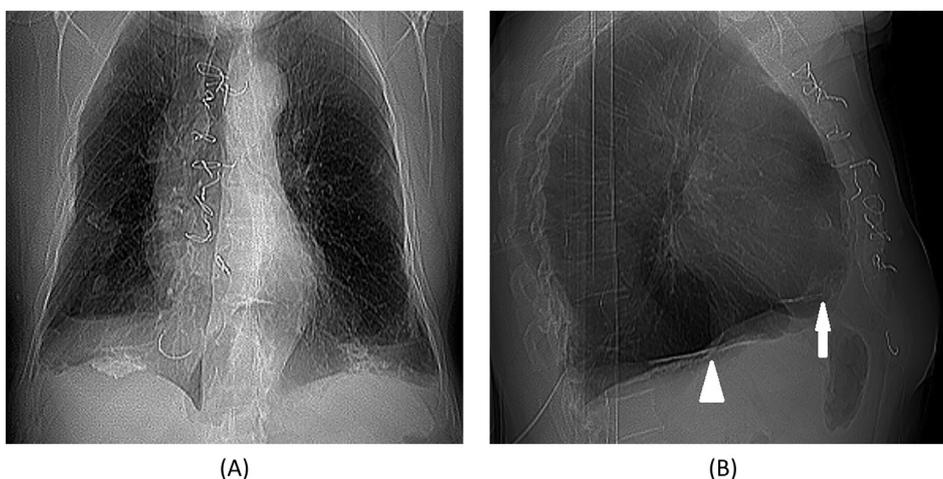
Chest X-ray. Bilateral pleural thickening was noted in PA view (A), while pericardial and diaphragmatic pleural calcification are noted in lateral view (B).
